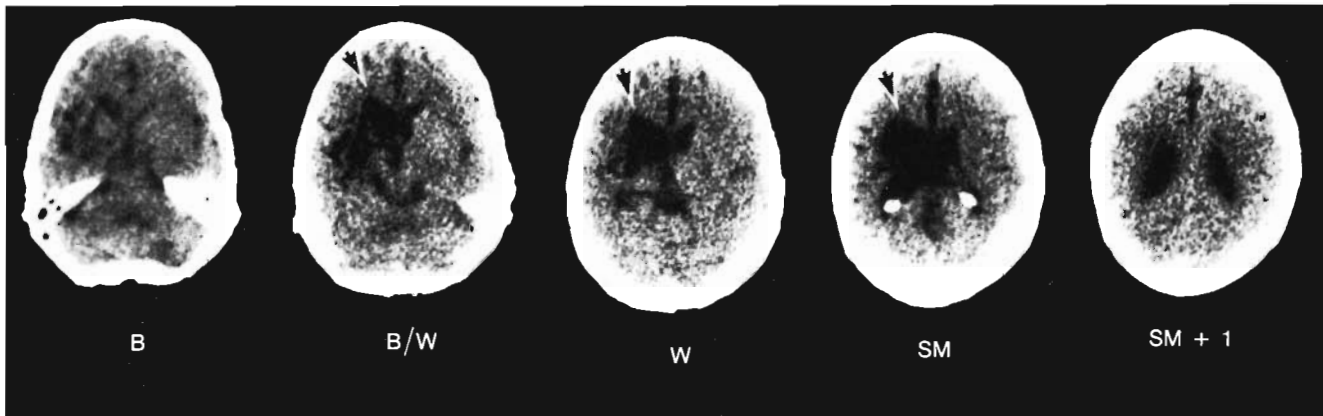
Computed tomographic scan (case 7) done 15 months after stroke. Subcortical lesion site is capsular-putaminal with both anterior-superior and posterior lesion extension. Frontal lobe lesion in periventricular white-matter extends anteriorly beyond frontal horn, including fibers to genu of corpus callosum (arrows).
